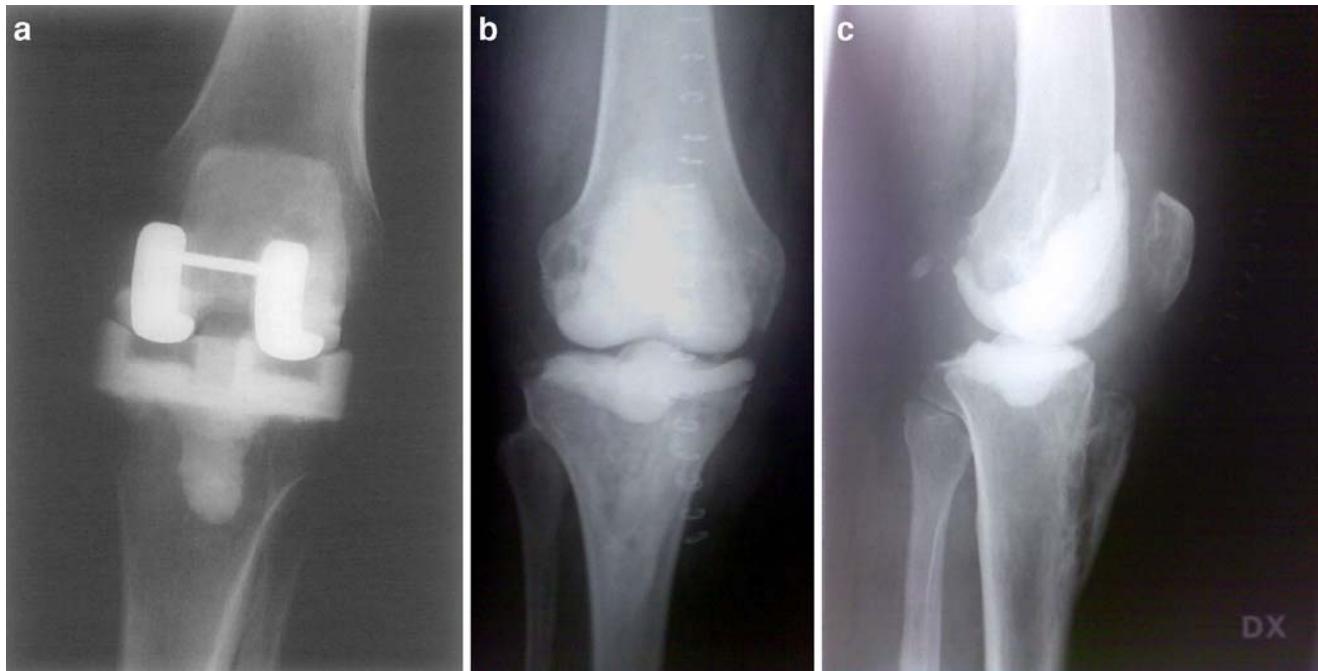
a, b, c X-ray showing commercial PMMA spacer and the one described in this paper
